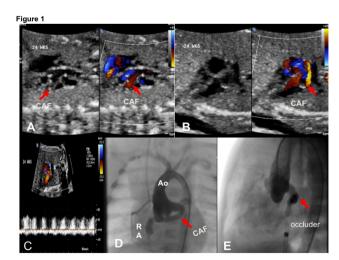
A,B, C - 2D and Color Doppler shows the presence of a fistulous tract arising from the left coronary artery and into the right atrium (RA). The filling of the fistulous tract is antegrade during ventricular diastole and reversed during systole. D- Selective left coronary artery angiography showing dilation of the fistulous tract and draining into the RA.E- After total closure of CAF. Ao- aorta; CAF - coronary artery fistula: RA - right atrium.
